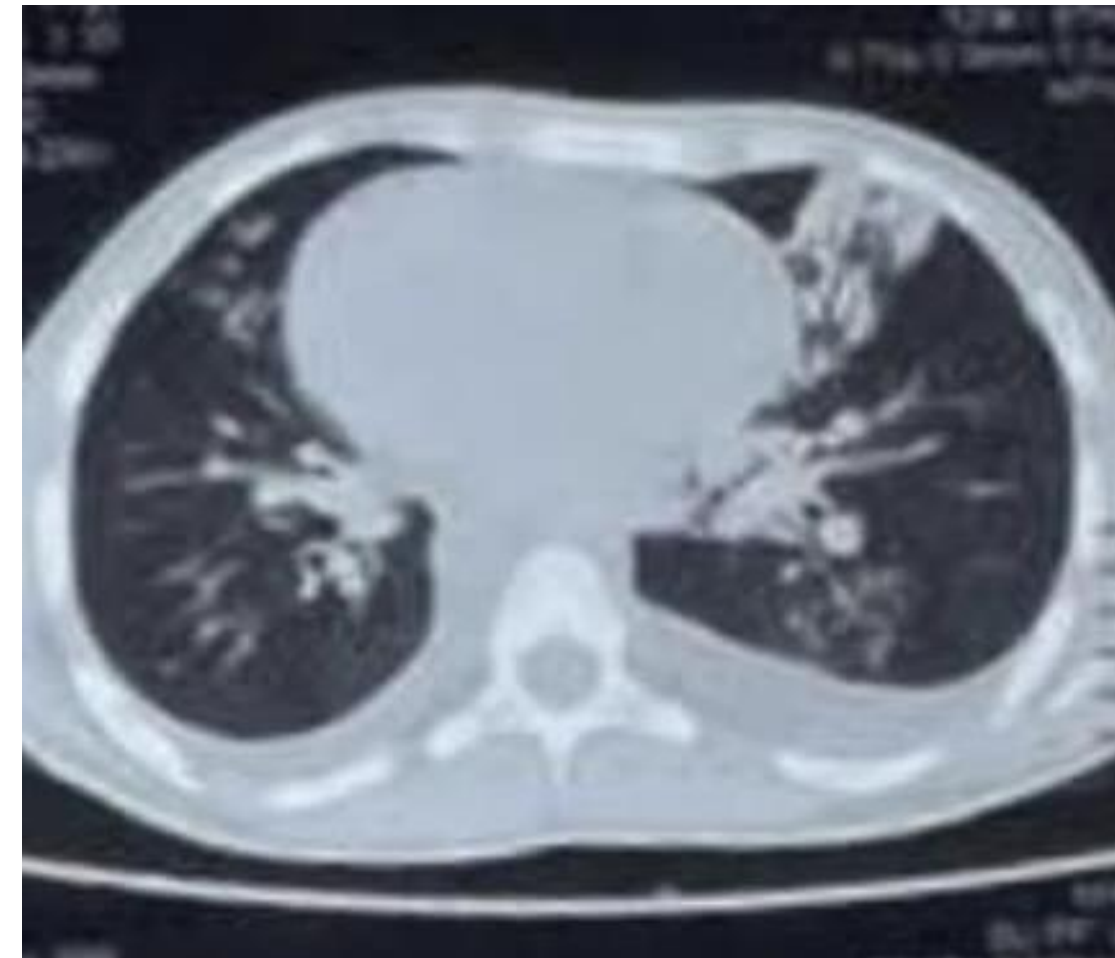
HRCT scan chest shows tractional bronchiectatic changes
